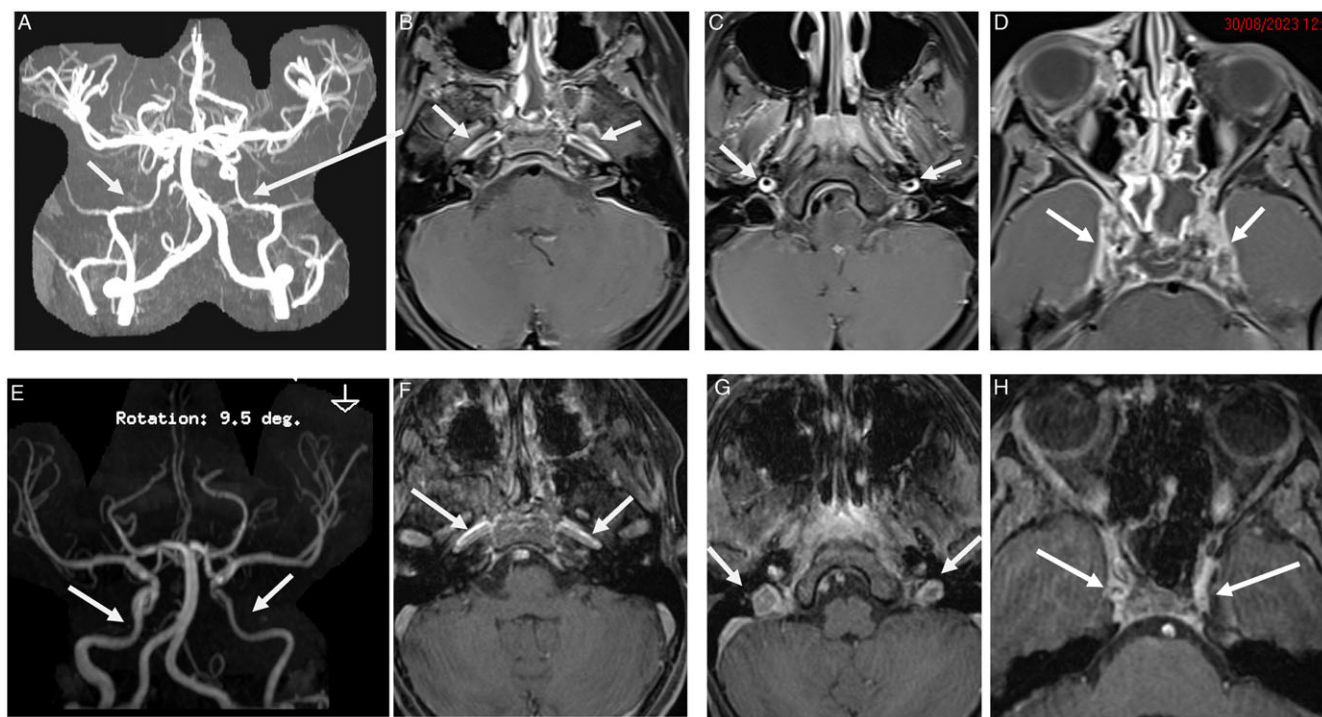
(a) MRA time of flight (ToF) demonstrates significant narrowing of the petrous and cavernous segments of ICA on both sides (arrows); (b-c) axial T1WI with fat saturation (FS) and gadolinium (Gd) shows bilateral wall thickening and enhancement of the same segments of ICA and (d) demonstrates distended enhancement of the cavernous sinus on both sides, more prominent on the right side with small filling defects within. Follow-up MRI 1.5T after 8 weeks: (e) MRA ToF demonstrates resolution of the narrowing of the petrous and cavernous segments of the right ICA residual narrowing of the left ICA; (f-g) axial T1WI (FS, Gd) shows decreased wall thickening and resolution of wall enhancement of the same segments of ICA on both sides and (h) demonstrates significant interval improvement of the distension with normal enhancement of the cavernous sinuses on both sides and with no filling defects within. AIS = acute ischemic stroke; ICA = internal carotid artery; MRA = magnetic resonance angiography.
